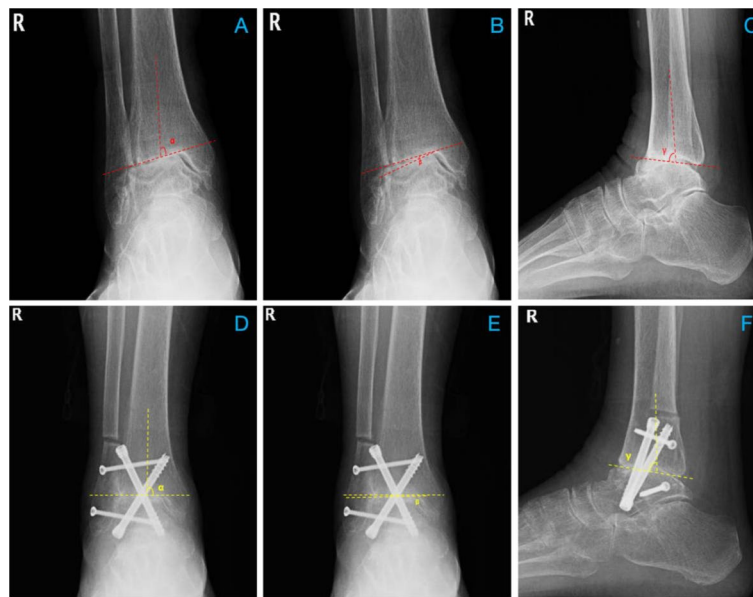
Preoperative X-ray images of the right ankle taken in a weight-bearing position showing Takakura stage IV arthritis and postoperative images showing the two 6.5 mm double compression screws used to fix the tibiotalar joint and the two 3.5 mm cortical bone screws used to fix the lateral malleolus during ankle arthrodesis with the lateral approach. The radiological alignment indicators at the last follow-up after treatment are shown as well. At the last follow-up, the union status was good. A. Preoperative anteroposterior X-ray shows the medial distal tibia (MDTA) (α). B. Preoperative anteroposterior X-ray shows the talus tilt angle (TTA) (β). C. Preoperative lateral X-ray shows the anterior distal tibia angle (ADTA) (γ). D. Anteroposterior X-ray at the last follow-up shows MDTA (α). E. Anteroposterior X-ray at the last follow-up shows TTA (β). F. Lateral X-ray at the last follow-up shows ADTA (γ)
